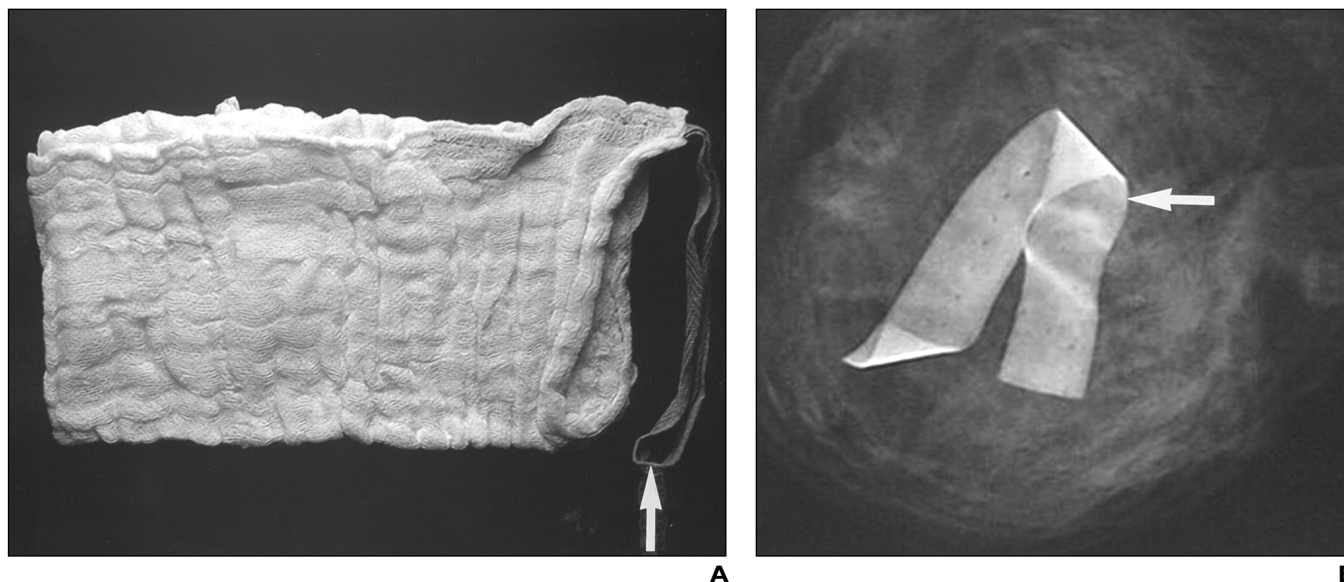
Photographic and radiographic appearances of typical laparotomy sponge.
